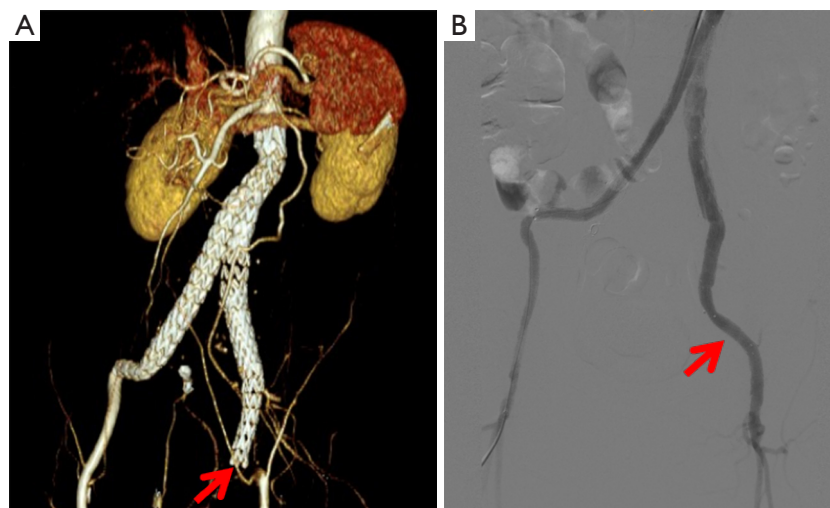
Preoperative CTA and intraoperative DSA images of the first IBO operation after EVAR. In March 2021, three months after EVAR surgery, the patient developed a significant exacerbation of left limb claudication. CTA showed occlusion of the left iliac branch, and the distal end of bilateral iliac branch stents twisted into angles with the iliac artery (A). The patient extended stent. After operation, DSA showed that the blood flow of iliac branch was unobstructed (B). CTA, computed tomography angiography; DSA, digital subtraction angiography; IBO, iliac branch occlusion; EVAR, endovascular repair of abdominal aortic aneurysm.
